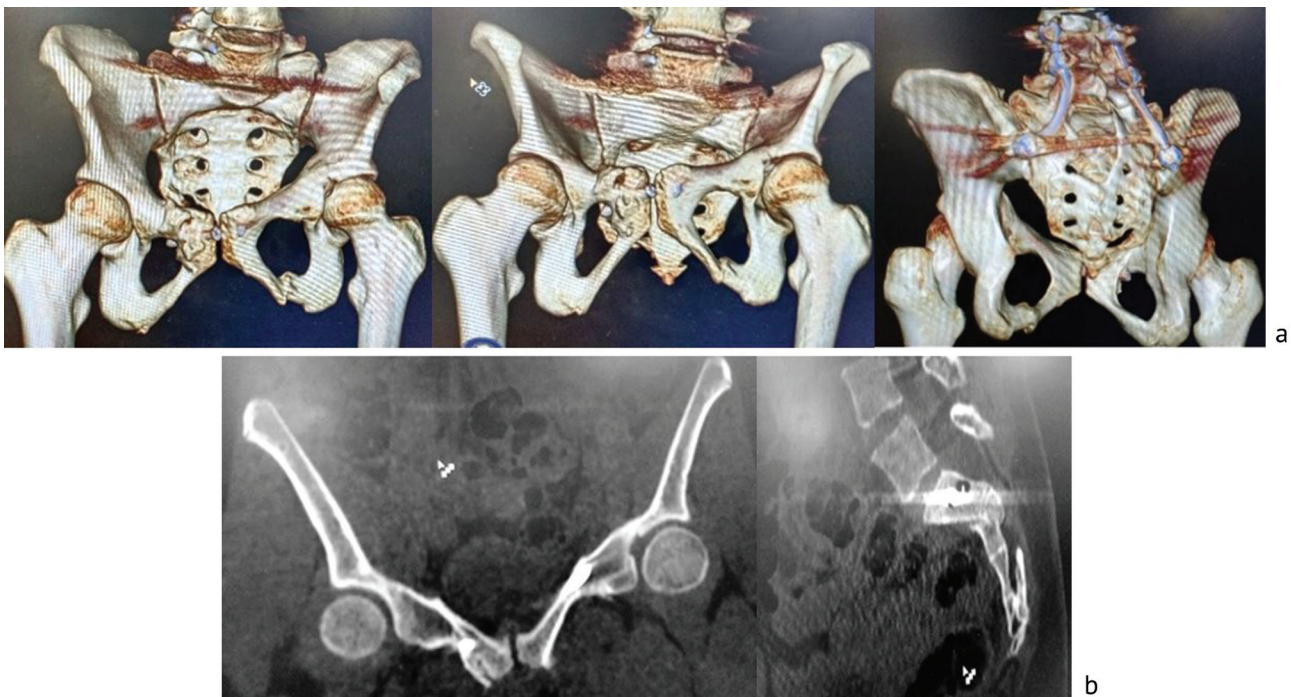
Computed tomography scans of the pelvis at six months of surgery showing (a) 3D reconstruction; (b) scans in frontal and sagittal planes
